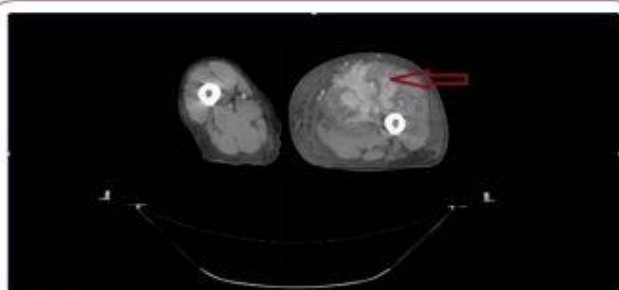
CT Scan of left thigh mass.
